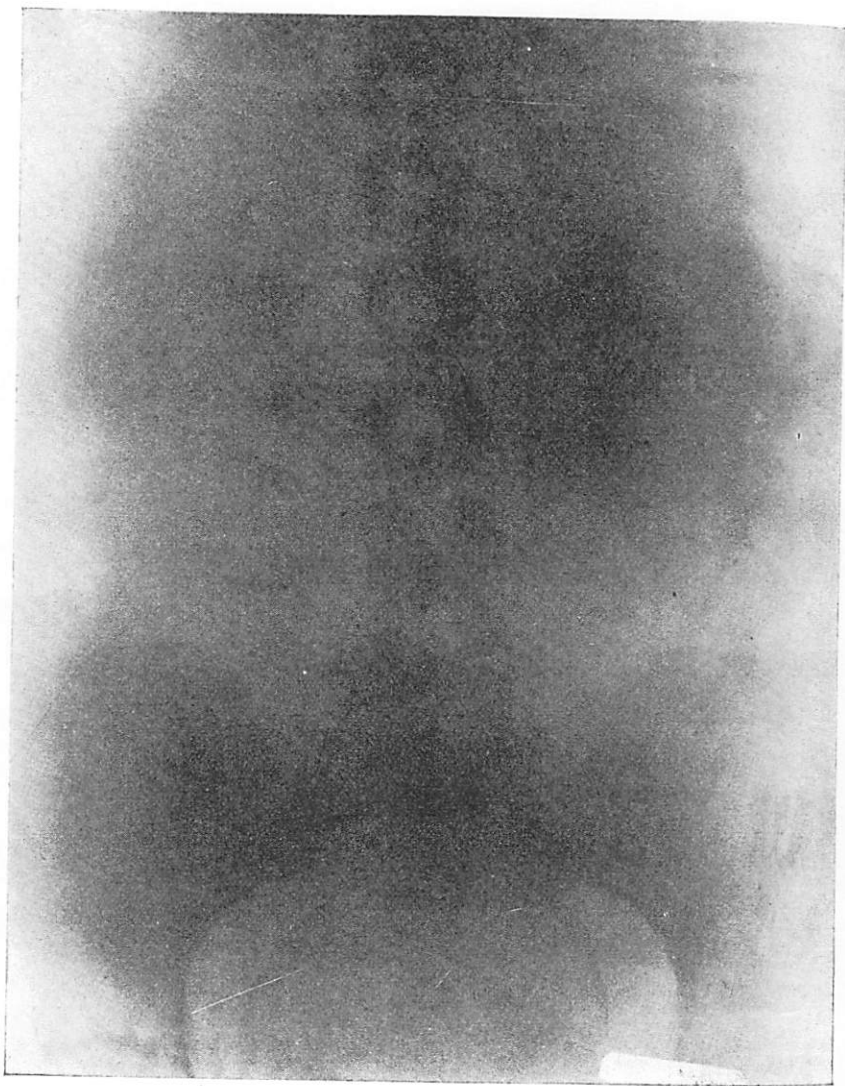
Mrs. G. B., x-ray diagnosis of triplets at seven months; delivered at eight and one-half months, all born alive.
